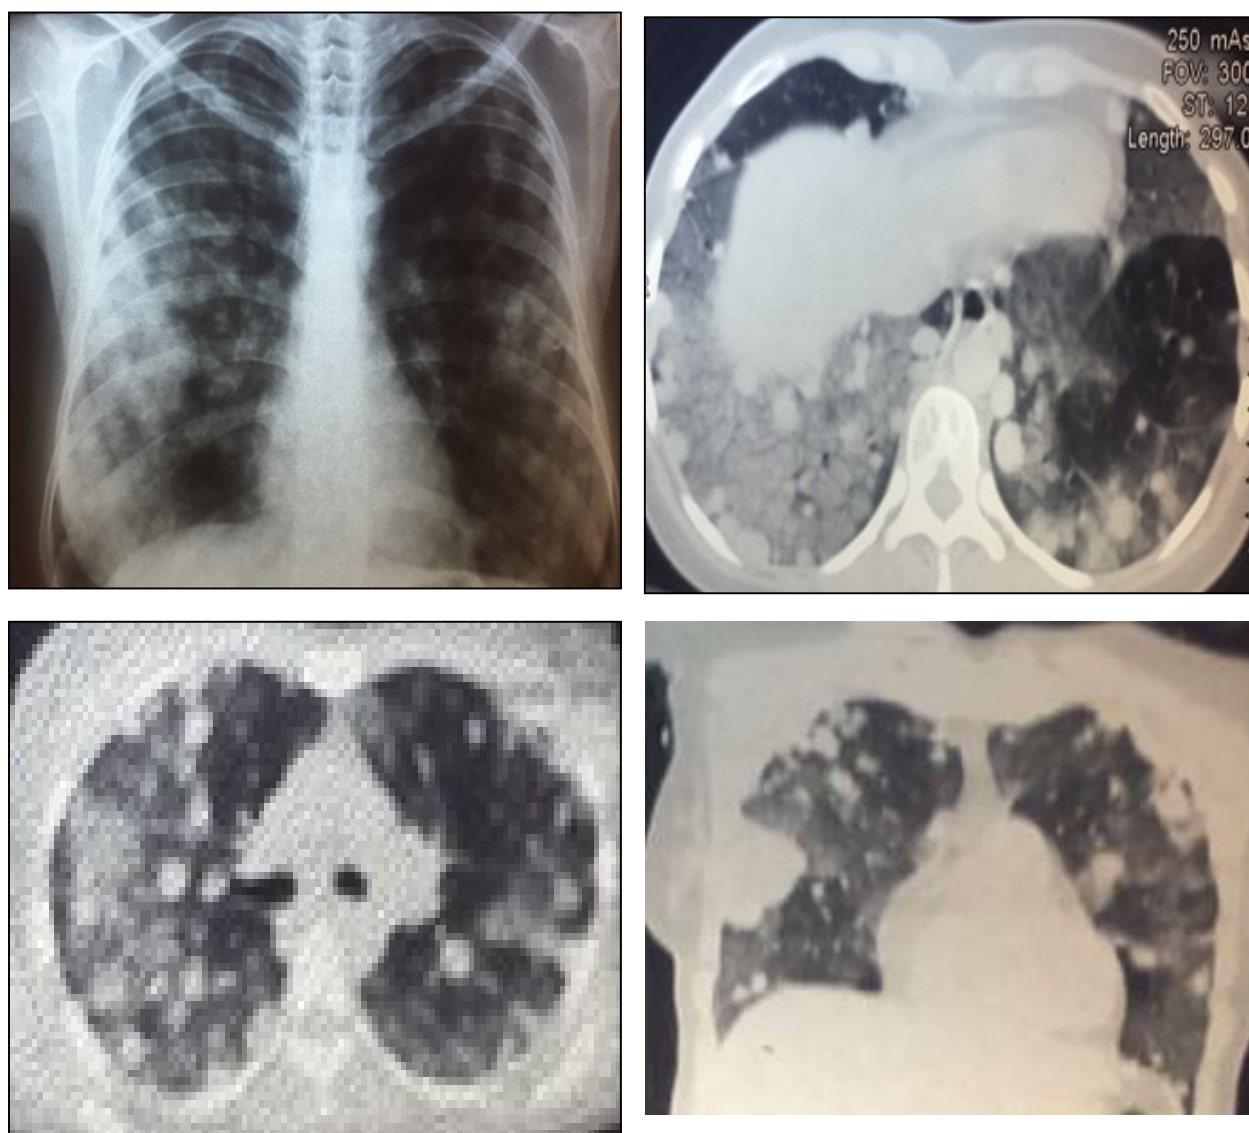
Left upper panel (Chest radiograph): bilateral nodular and right midlung zone homogeneous opacities; right upper and lower panels: multiple bilateral nodular opacities, right mid-lung mass, and airspace disease at the bases (Chest CT).
